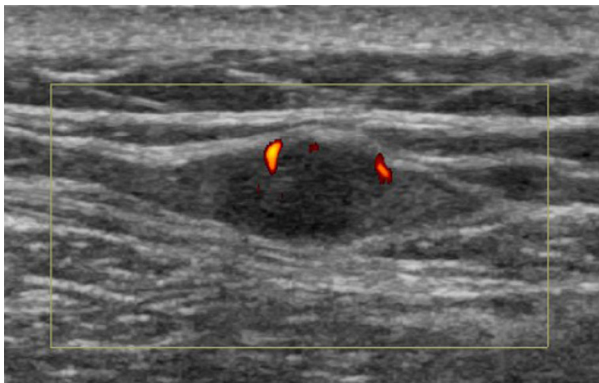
Ultrasound scan of the chest wall shows the hypoechoic lesion with vascularity.
